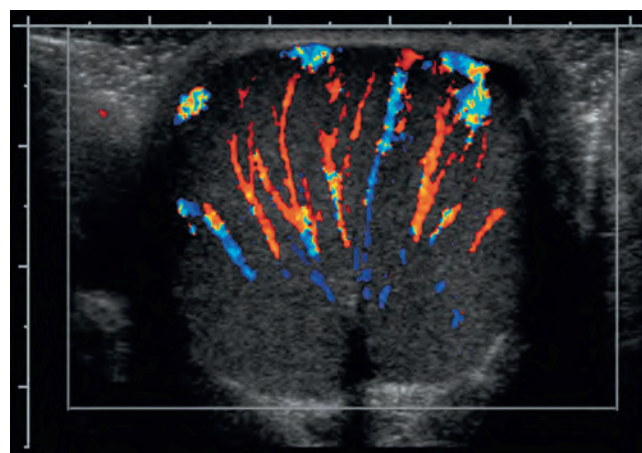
Doppler ultrasound image of testis demonstrating spokelike radiation of testicular vessels originating from the mediastinum testis.
